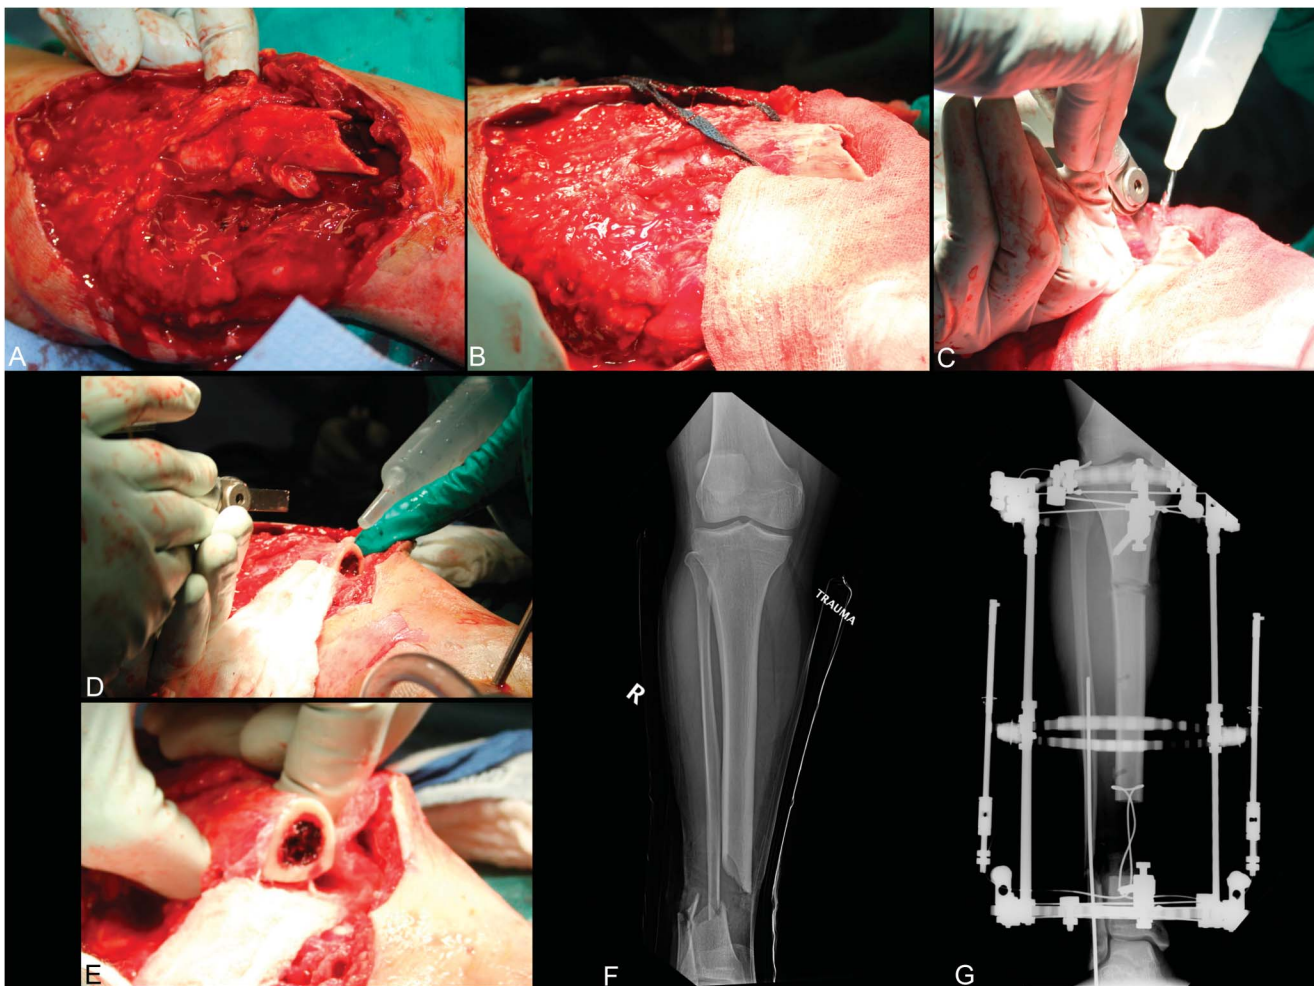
A, Picture of a bone end from an open tibia fracture after opening wound at the time of second debridement. B, Appearance of bone end after wound debridement and irrigation showing stripping of the bone end and no bleeding distally. C, D, Bone cut is performed using a low-energy saw. Constant iced saline irrigation of the saw blade is performed, and the saw is paused intermittently during the cut to assure that there is no thermal necrosis of the bone end. E, Examination of the bone end after osteotomy reveals healthy bleeding bone circumferentially with a 100% intact cortical rim. This is the ideal situation for bone preparation. F, G, Radiographs of an open tibia fracture defect before and after osteotomies were performed to prepare for bone transport. Note that the cuts are flat and orthogonal to the long axis of the bone in both coronal and sagittal planes.
